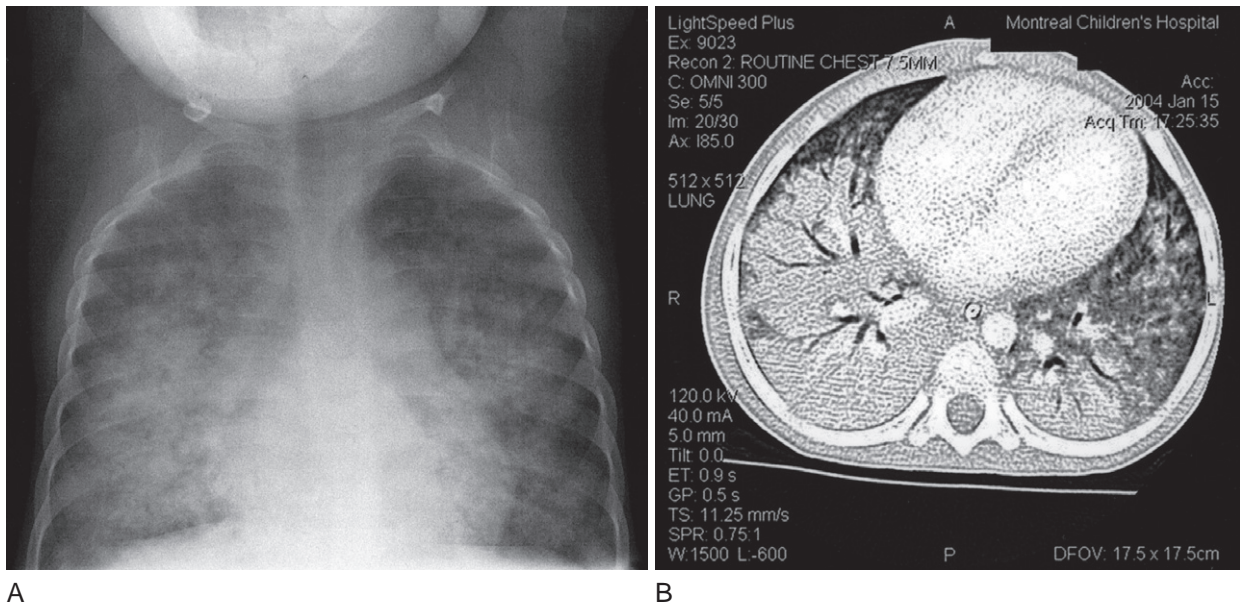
A, Three-year-old child recently immigrated from Africa presented with a history of weakness and coughing, having been treated for pulmonary tuberculosis 2 years previously. Respiratory distress worsened, and intubation was required. A, Plain radiograph demonstrates a lung infiltrate with an alveolar pattern. B, Diffuse consolidation with air bronchogram, especially in the right lower lobe, can be appreciated on computed tomography. Human immunodeficiency (HIV) was suspected and later confirmed. Bronchoscopy and bronchoalveolar lavage were not diagnostic. Lung biopsy revealed lymphoid interstitial pneumonitis. He was treated with steroids and triple antiretroviral therapy and rapidly recovered.
